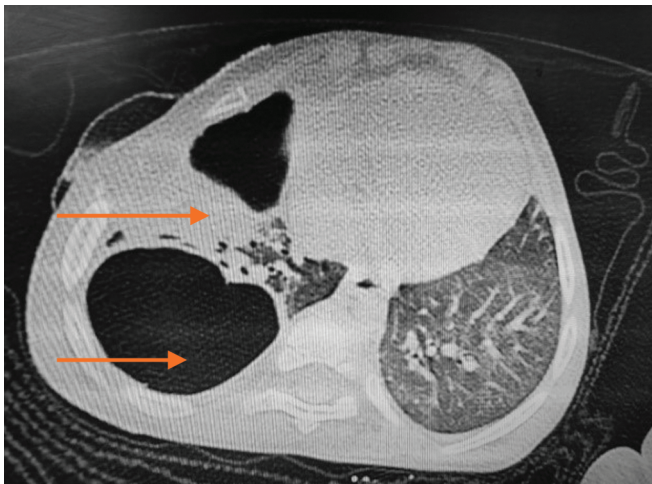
CT thorax showing lung destruction, extensive fibrosis and cavitary changes
